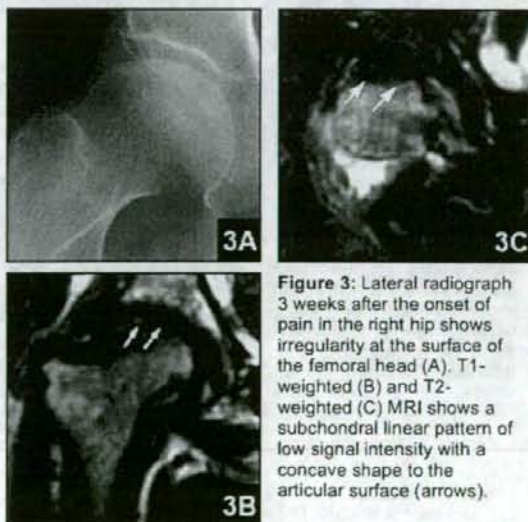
Lateral radiograph 3 weeks after the onset of pain in the right hip shows irregularity at the surface of the femoral head (A). T1-weighted (B) and T2-weighted (C) MRI shows a subchondral linear pattern of low signal intensity with a concave shape to the articular surface (arrows).
